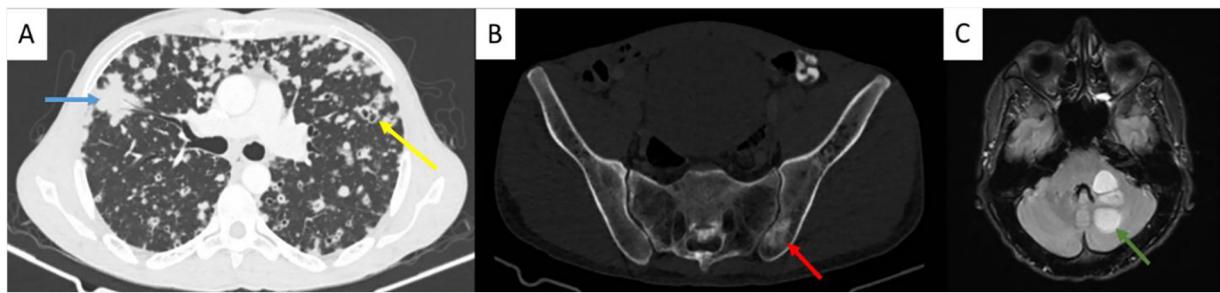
(A) Chest CT Scan revealing a solid mass with spiculated margins (blue arrow) in contact with the anterior segmental bronchus of the right upper lobe, measuring 37 mm × 33 mm, associated with numerous bilateral lung nodules, some of them cavitary (yellow arrow) (B). Abdominal CT scan showing left iliac bone metastasis (red arrow). (C) Post-operative brain MRI showing left cerebellar hemisphere metastases (green arrow).
